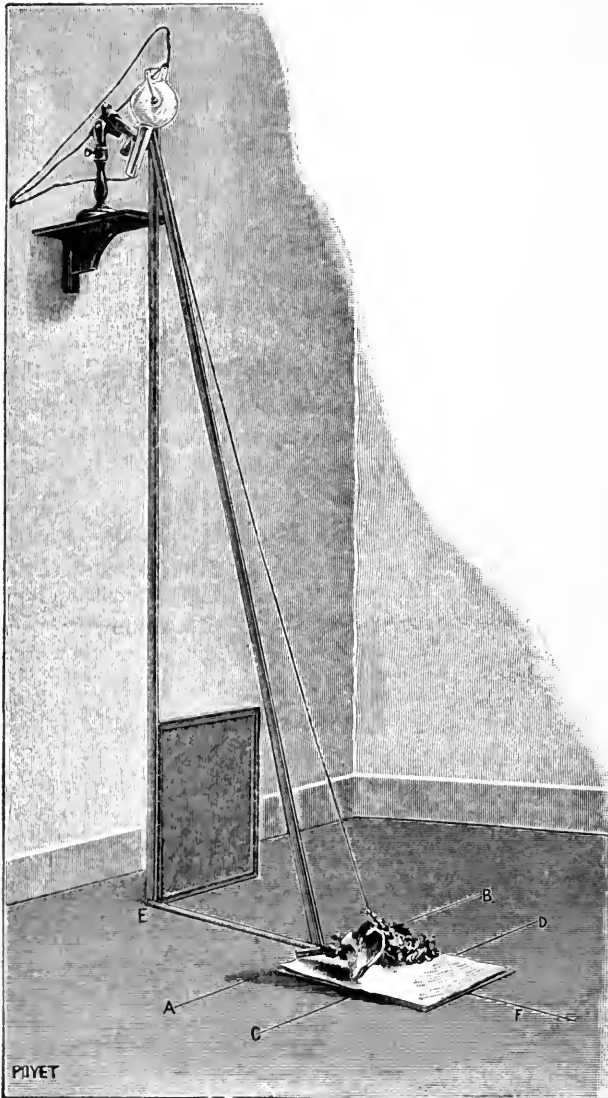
Varnier's arrangement for radiography.
